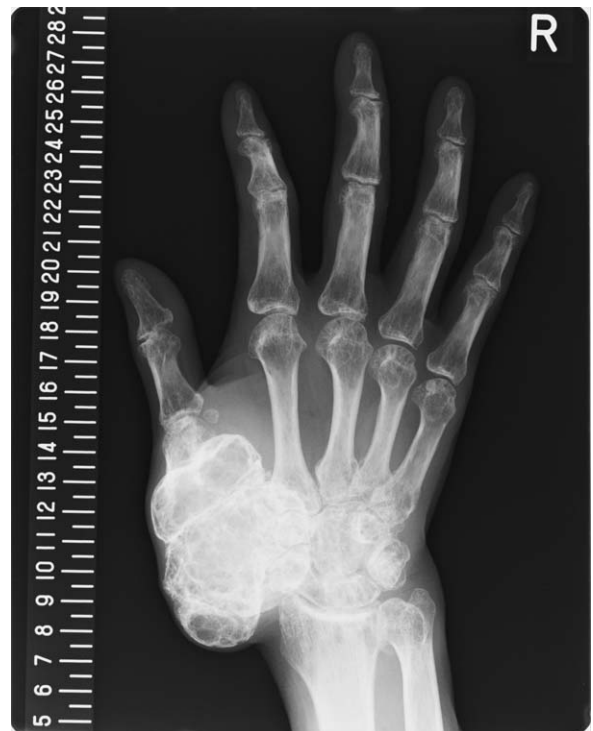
X-ray image of the right hand prior to surgery. The metastatic lesion to the trapezium had increased in size, formed new bone resembling a birdcage, and become involved the first metacarpal bone.
